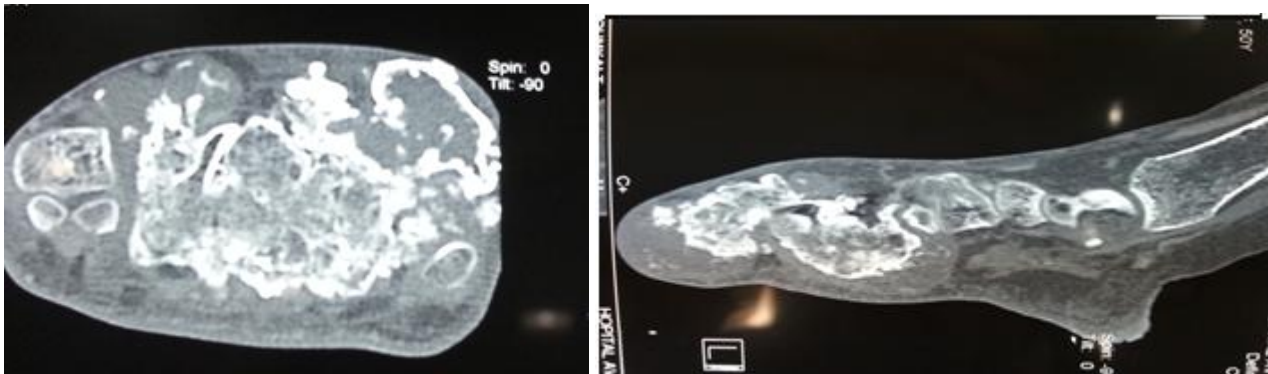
Computed tomography (CT) of foot shows cortical destruction, with invasion of the surrounding soft tissues and presence of points of calcification
